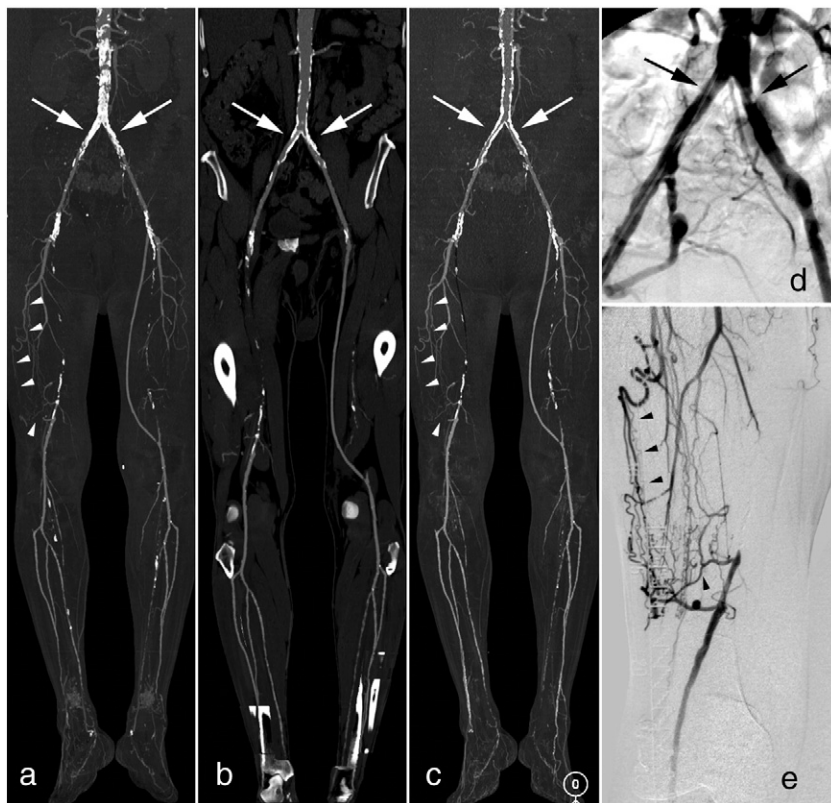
A 64-year-old male patient with a known occlusion of the right superficial femoral artery and a femoro-popliteal bypass on the left was referred for CTA due to PAOD IIb in the right leg. (a) MIP showed collateral vessels (arrowheads), but the severely calcified iliac arteries could not be evaluated (arrows); (b) On mpCPR, stenosis in both iliac arteries was detected (arrows), but collateral vessels were not depicted; (c) Only the hybrid reformation depicted both iliac stenosis (arrows) and the collateral vessels (arrowheads); (d+e) Preoperative DSA confirmed the iliac stenosis (arrows) and the collateral vessels (arrowheads).
